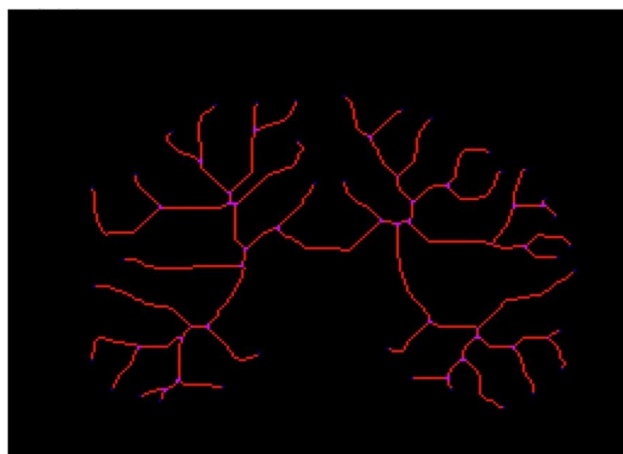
Pre-processing of the magnetic resonance image of the brain: A - non-segmented coronal section after removal of background structures, B - binary silhouette image after segmentation, C - skeletonized image.
